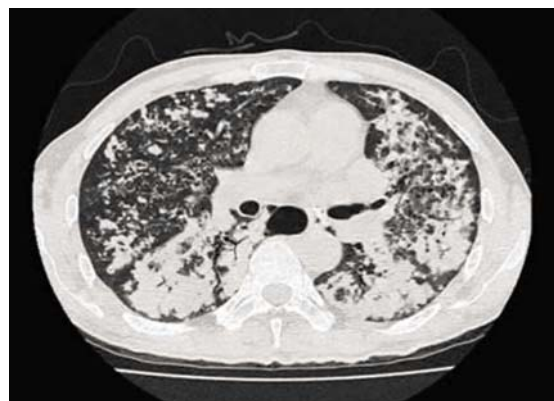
Chest CT scan revealed bilateral non-calcified pulmonary nodules and masses, and areas of consolidation. Air bronchograms could be seen in the areas of consolidation. Multiple mediastinal lymph nodes enlargement was revealed, which were light uniform enhanced without necrosis.
